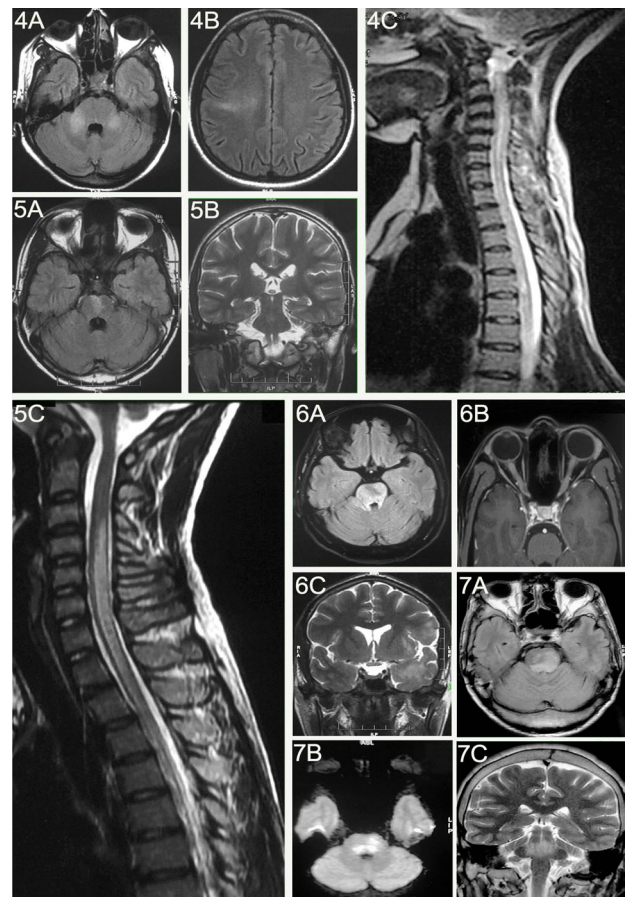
MRI-brain showing bilateral MCP sign(4A) and right frontoparietal cerebritis (4B); LETM (4C); medial longitudinal fasciculus hyperintensity (5A); central pontine hyperintensity (5B); LETM (5C); pontine hyperintensity with bilateral MCP sign(6A); contrast-enhancement of bilateral optic nerves (6B); optic chiasmal hyperintensity (6C); pontine hyperintensities(7A), with diffusion restriction (7B) and coronal-T2 ponto-cerebellar hyperintensity (rhombencephalitis)(7C).
